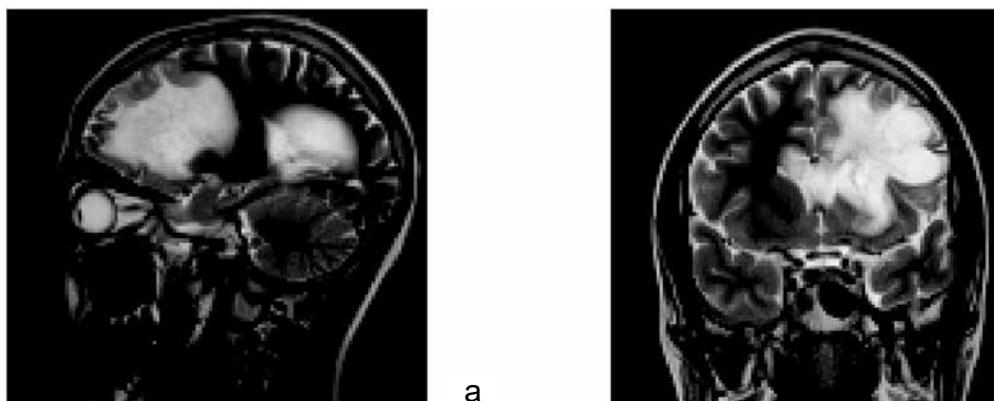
T2-weighted images in sagittal (a) and coronal (b) planes. Extensive hyperintense areas of white matter mainly in the left cerebral hemisphere with extension through the corpus callosum
